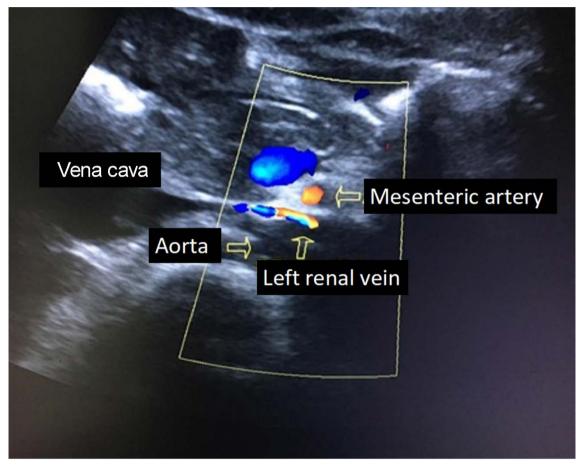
Detail of the Doppler ultrasonography in cross-sectional view, showing the left renal vein compressed by the superior mesenteric artery, aorta, and other adjacent anatomic structures.
